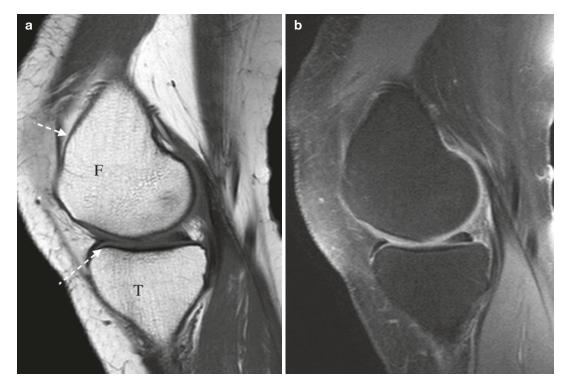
MRI of the cortex (dashed arrow) and normal marrow on (a) Sag T1 and (b) Sag T2FS. F femur, T tibia
